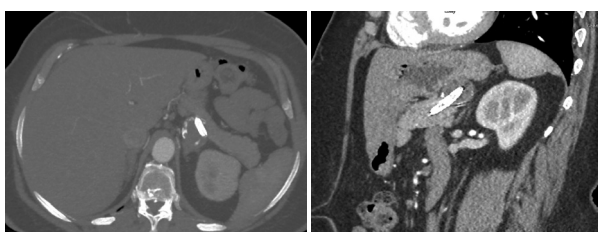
Follow-up CTA without endoleaks
